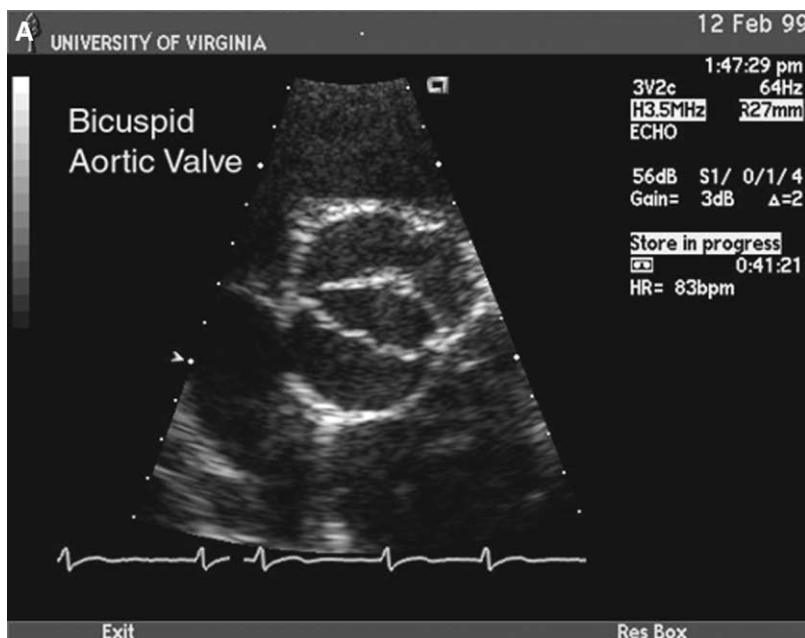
(A) Two-dimensional echocardiogram of a bicuspid aortic valve, demonstrating fusion of the left and right coronary cusps. This patient has adequate valve opening to exclude significant stenosis, and high level exercise would be permissible. (B) Doppler echocardiogram of a patient with severe aortic stenosis; the peak transvalvular gradient was 74 mm Hg. Using the continuity principle, the patient's estimated aortic valve area is 0.6 cm². This patient would not be allowed to participate in high-level sports whether symptomatic or asymptomatic.
